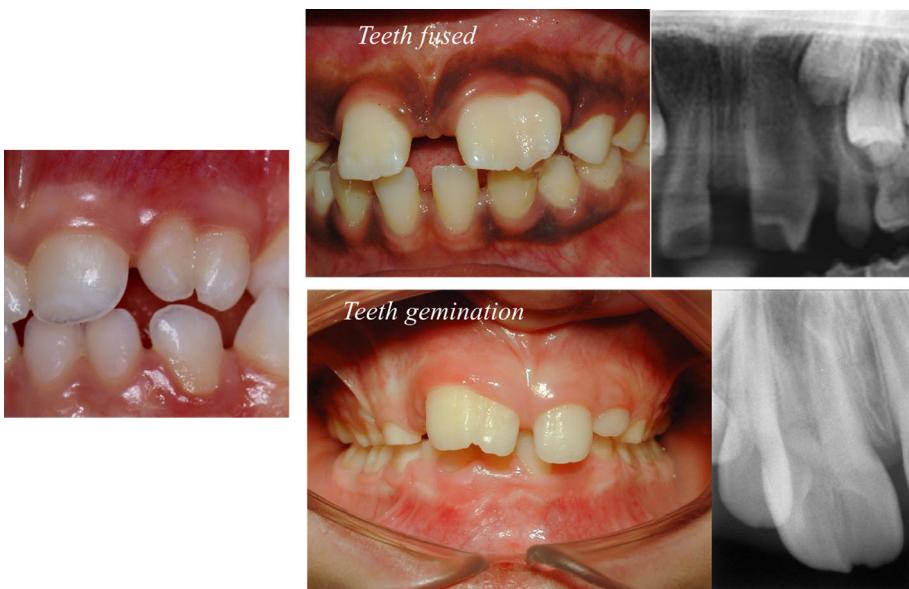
Double teeth in the deciduous dentition. Teeth fused: Fusion of the central incisor with the lateral incisor. Radiograph exhibit the absence of the lateral incisor. Teeth gemination: Tooth germination of right maxillary incisor—clinical aspect and radiograph. Gemination concerned the crown and the beginning of the root. The lateral incisor is present, so the patient has a normal number of teeth [Color figure can be viewed at wileyonlinelibrary.com]
